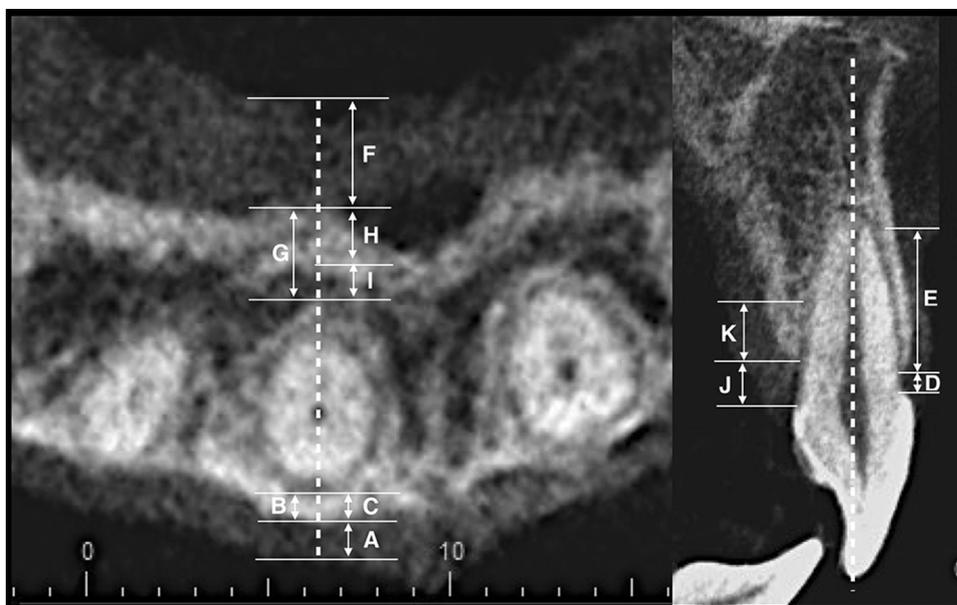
CBCT measurements. CBCT parameters of (A) to (E) on labial aspect: (A) labial gingival thickness, (B) labial alveolar bone thickness, (C) labial cortical bone thickness, (D) labial alveolar bone height, (E) labial cortical bone height. CBCT parameters of (F) to (K) on palatal aspect: (F) palatal gingival thickness, (G) palatal alveolar bone thickness, (H) palatal cortical bone thickness, (I) palatal cancellous bone thickness, (J) palatal alveolar bone height, (K) palatal cortical bone height.
